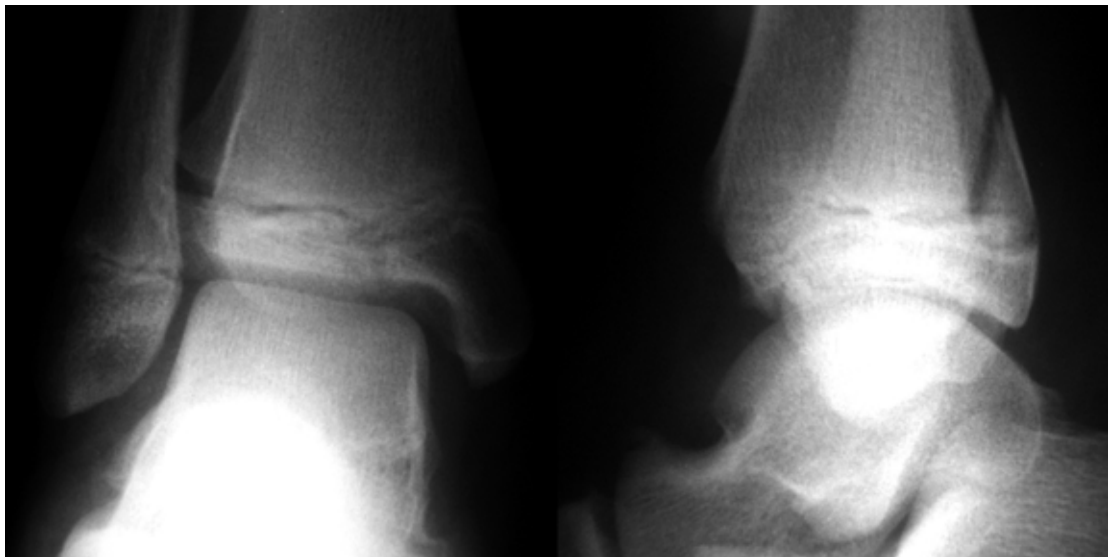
Plain X-ray of the ankle.
